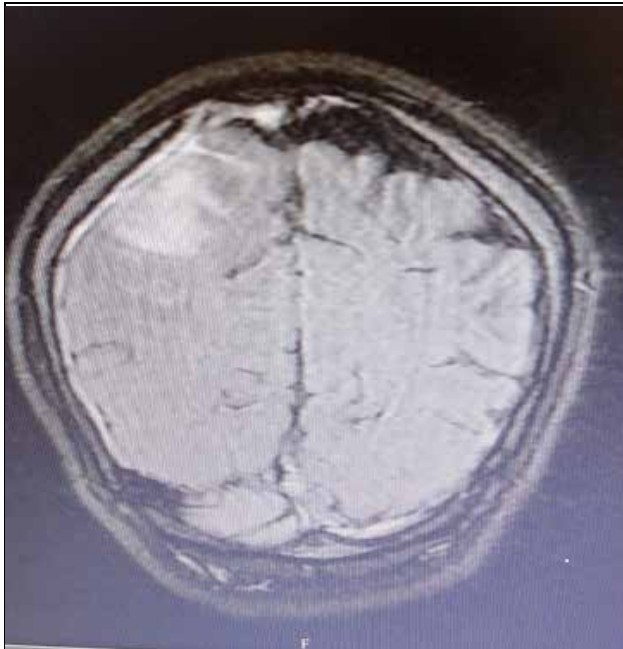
MRI Brain showing venous infarction with minor hemorrhagic component within the right parietal lobe.
